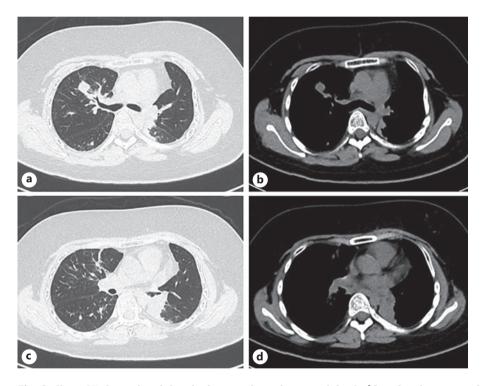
Chest CT showed nodular shadows in the right upper lobe (\mathbf{a}, \mathbf{b}) and at electasis in the left lower lobe of the lung (\mathbf{c}, \mathbf{d}) . CT, computed tomography.
